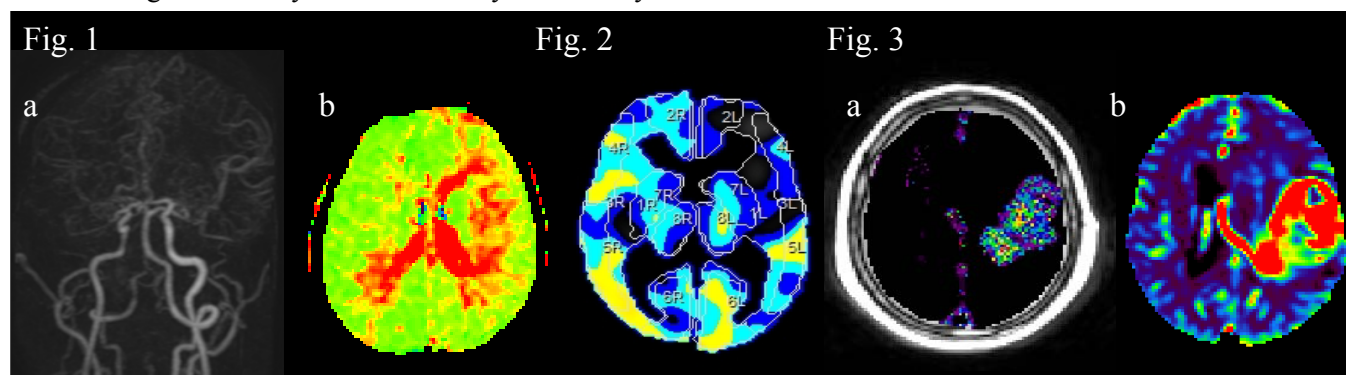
Moyamoya disease a. MIP image of 4D-MRA shows hypoplasia of bil. MCA. b MTT image calculated from DSC-MRI shows cerebral perfusion impairment in left hemisphere. Fig.2 Lt. IC occlusion. CVR image is obtained from DSC-MRI data with ACZ challenge. It shows a decreased CVR in left hemisphere. Fig.3 Glioblastoma multiforme a. Ktrans image obtained from DCE-MRI. b. CBV image obtained from DSC-MRI. These images show high blood volume and high permeability of the tumor.
